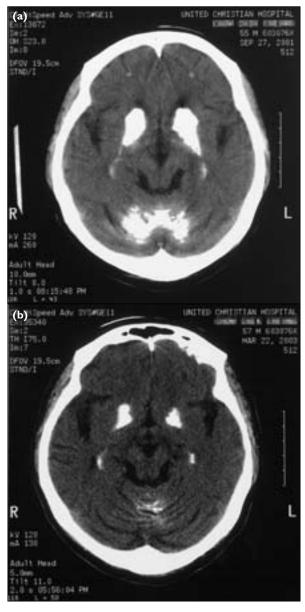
(a) Plain computed tomographic brain scan reveals cerebral atrophy and extensive calcification over basal ganglia, red nuclei, and dentate nuclei. (b) A repeated scan 2 years later reveals progressive cerebral atrophy and reduction in calcification
